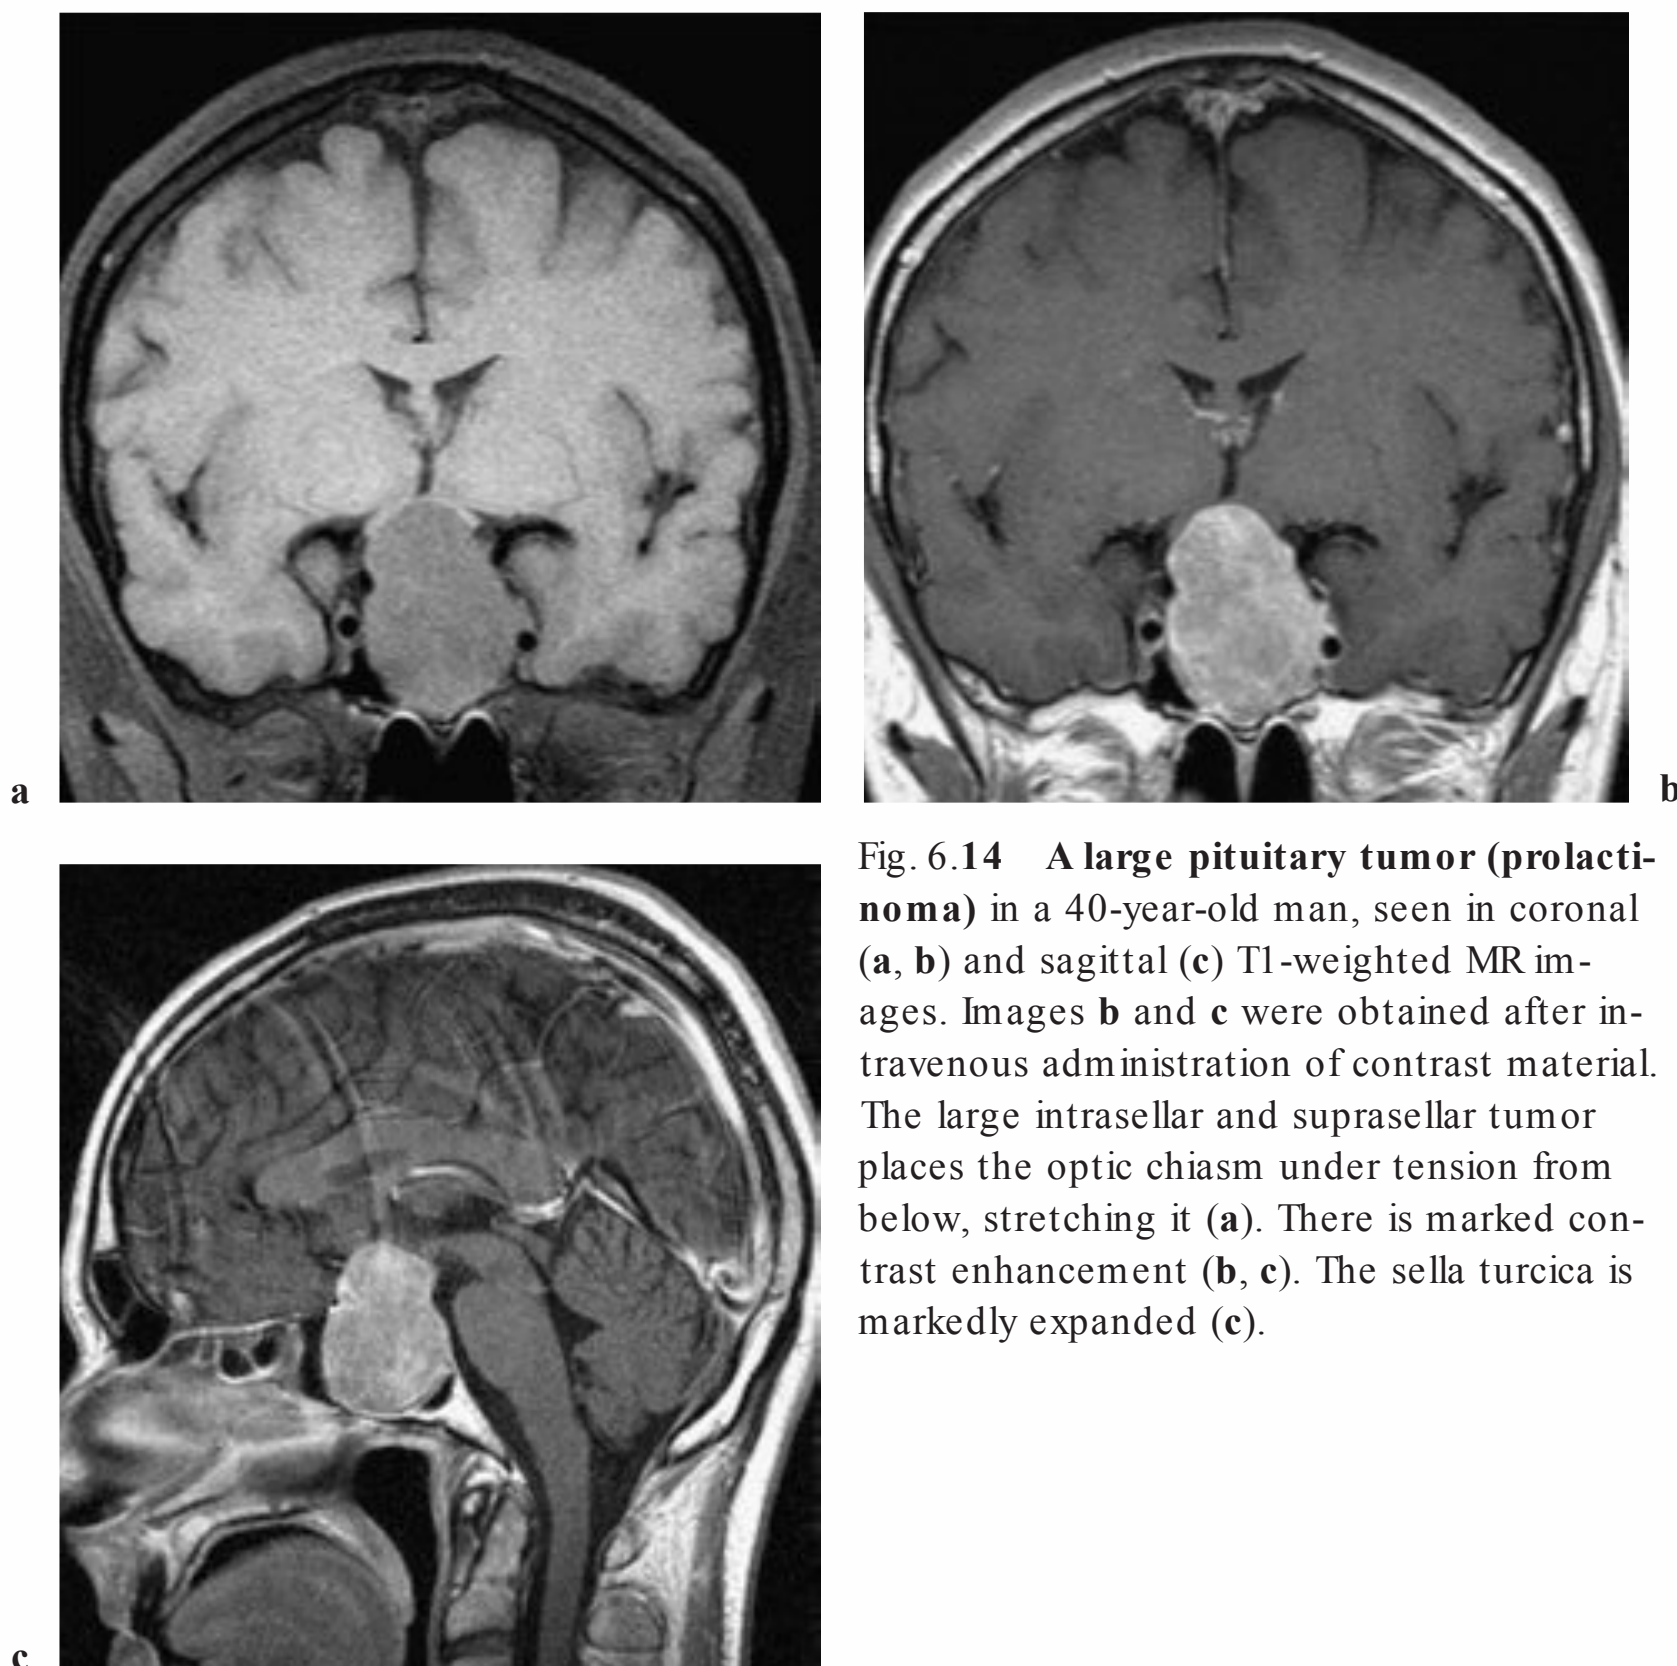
A large pituitary tumor (prolactinoma) in a 40-year-old man, seen in coronal (a, b) and sagittal (c) T1-weighted MR images. Images b and c were obtained after intravenous administration of contrast material. The large intrasellar and suprasellar tumor places the optic chiasm under tension from below, stretching it (a). There is marked contrast enhancement (b, c). The sella turcica is markedly expanded (c).
